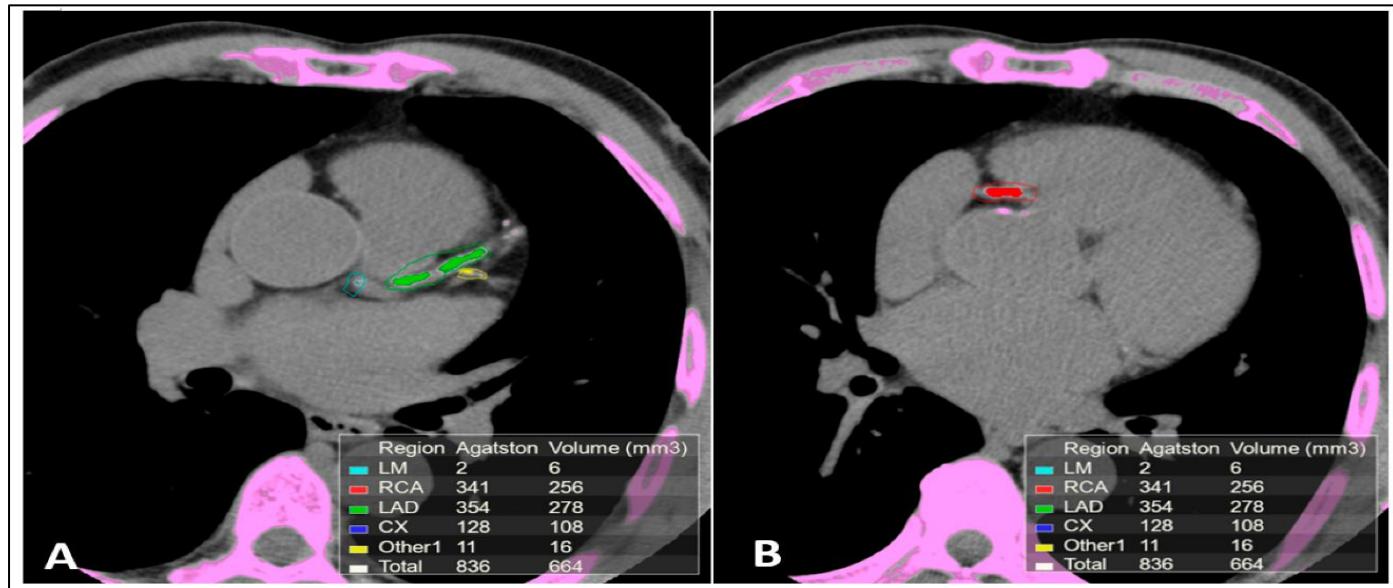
Coronary CT Images Showing Different Plaque Types in Atherosclerosis Imaging Review
